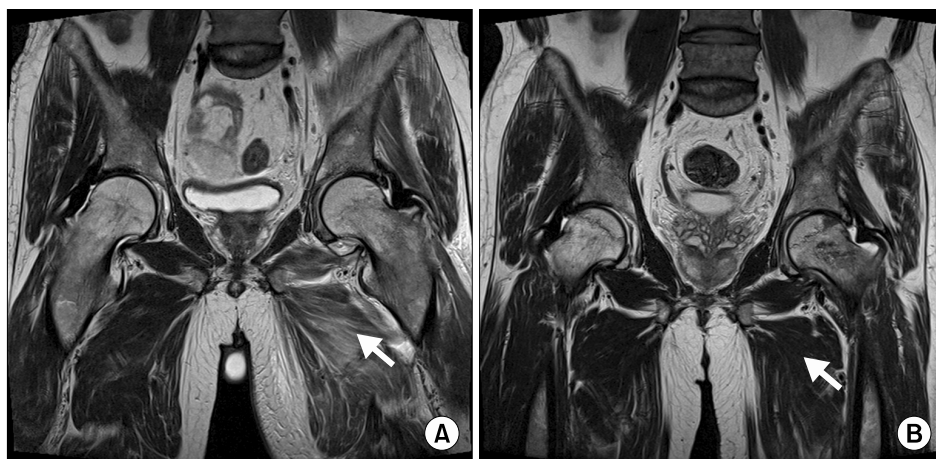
(A) Left Hip MRI 3 weeks after admission, showing slightly improved myositis and decreased joint effusion (arrow). (B) Left hip MRI after 6 months of antibiotic treatment, showing markedly improved myositis and abscess (arrow).
